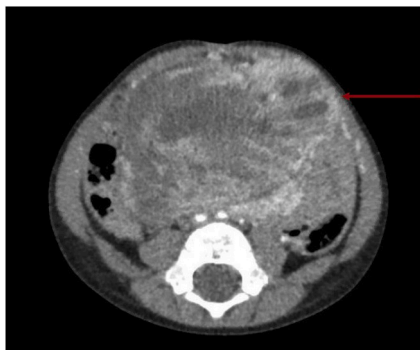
CT scan, Axial cut, showing the tumor prior to initiating treatment. Red arrow: Showing the tumor invading the abdominal wall musculature. (For interpretation of the references to colour in this figure legend, the reader is referred to the Web version of this article.)
